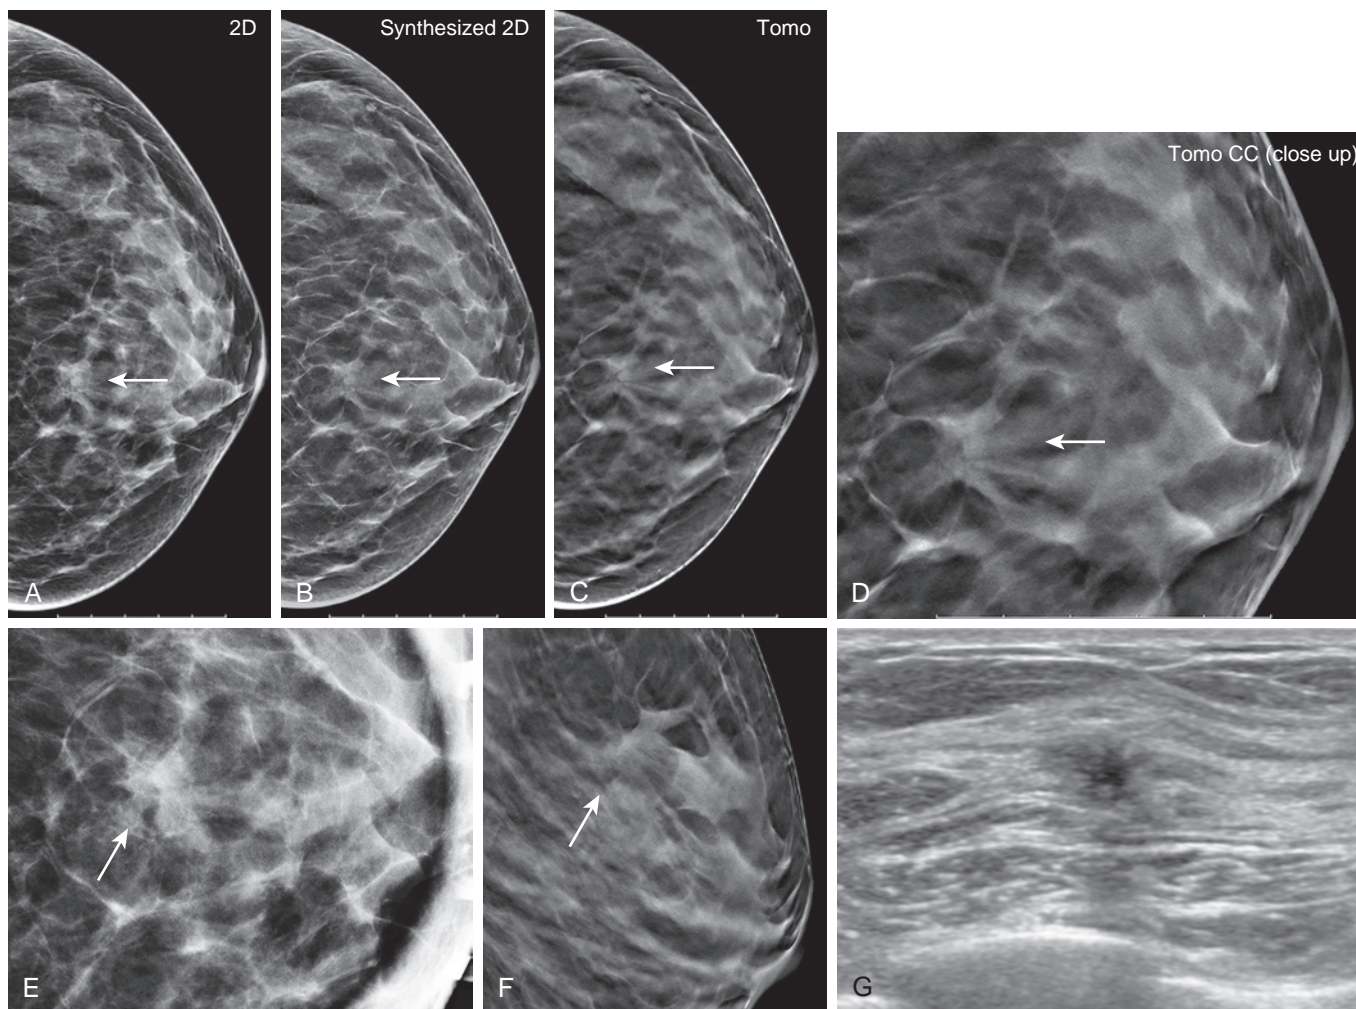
Tomosynthesis imaging of a woman with dense breast tissue. (A to D) A 52-year-old patient with extremely dense breast tissue presented for routine screening mammography. Architectural distortion (*arrows*) was noted in the left breast at mid/posterior depth. This was best demonstrated on the CC tomosynthesis and synthesized mammography views. 2D spot compression view (E) was performed along with a lateral tomosynthesis view (F), confirming the area of architectural distortion (*arrows*) better seen on tomosynthesis. (G) Breast ultrasound was performed and a 9-mm irregular, hypoechoic mass with architectural distortion was seen. US-guided core biopsy was performed, diagnosing a grade 2 invasive ductal carcinoma.
